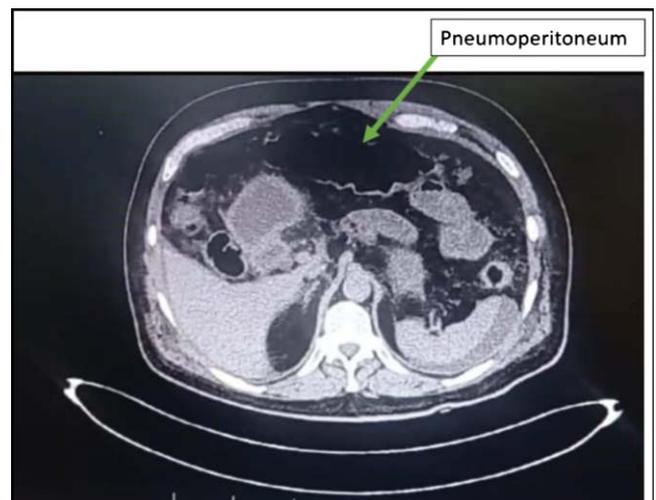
CT Scan Abdomen with Contrast showing pneumoperitoneum.
